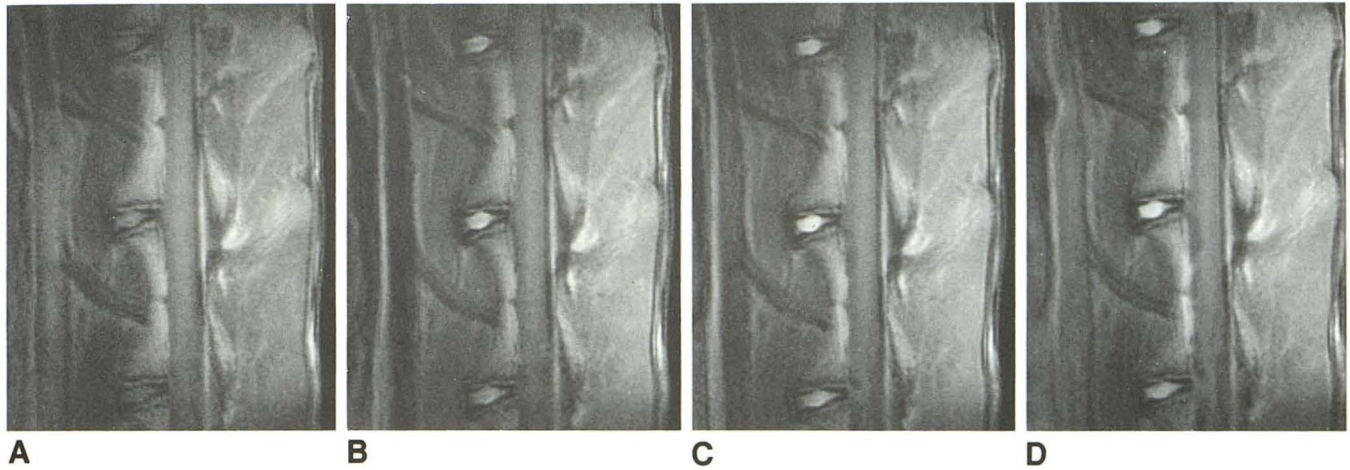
T1-weighted MR images before (A) and 10 (B), 30 (C), and 120 minutes (D) after intravenous administration of 2.8 mmol/kg of gadopentetate dimeglumine. Note that at 10 minutes, signal intensity increased near the end plates and subsequently increased diffusely in the disk.
